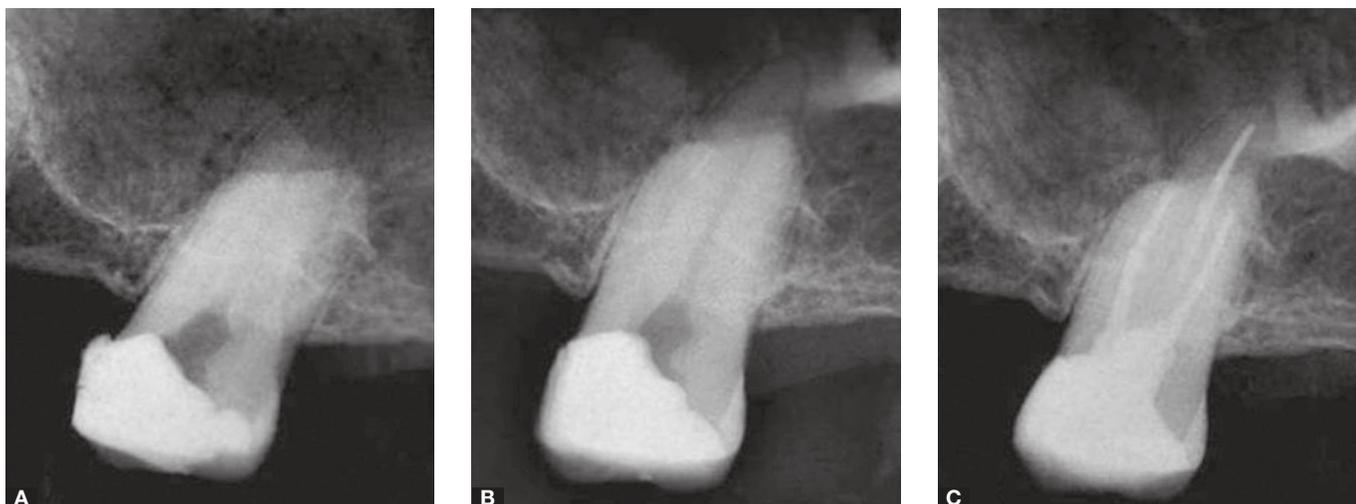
A) Initial radiograph; B) Fractured file in the mesiobuccal canal; C) Final radiograph.
